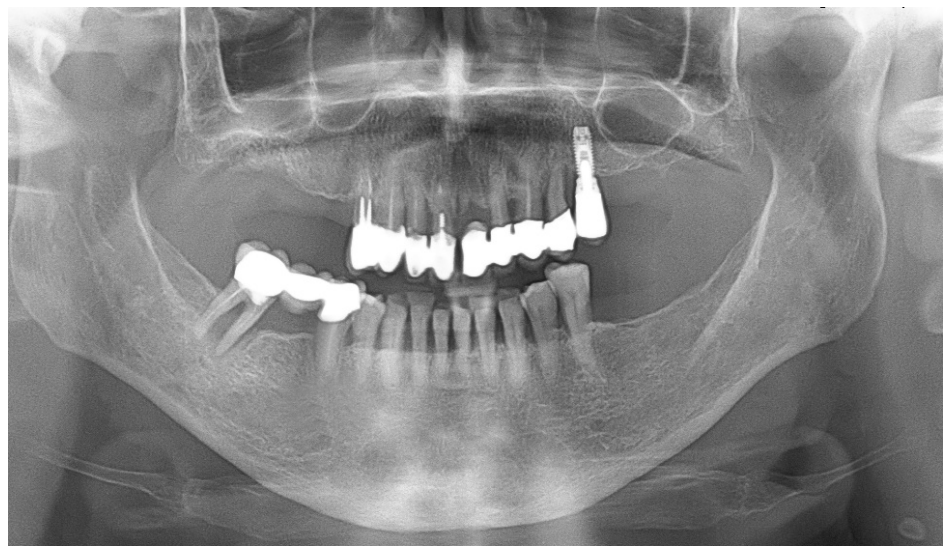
Preoperative panoramic radiograph. No radiographic signs of osteonecrosis were detected.
